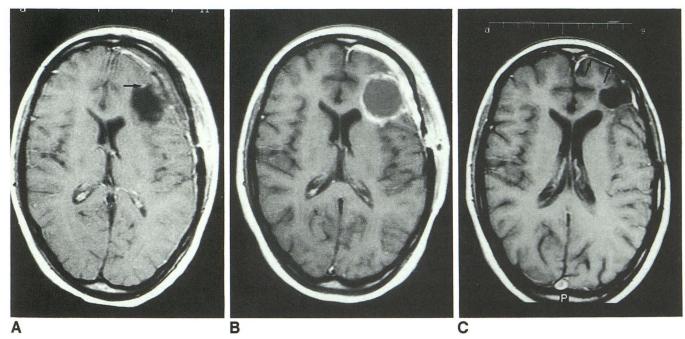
Axial T1-weighted MR image (600/20/2) obtained on the first day (A), 2 weeks (B), and 30 months (C) after extirpation of a glioblastoma.
